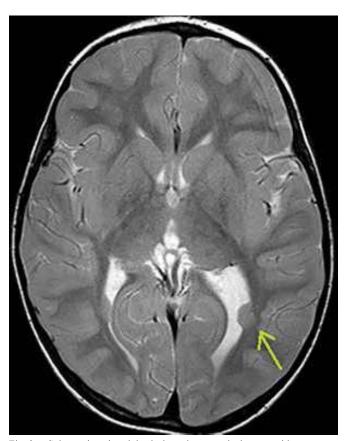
Subependymal nodular lesions that were isointense with grey matter extending into the lateral ventricles (arrow) at a transverse T2-weighted fast spin-echo MR image (subependymal heterotopia). MR = magnetic resonance.
